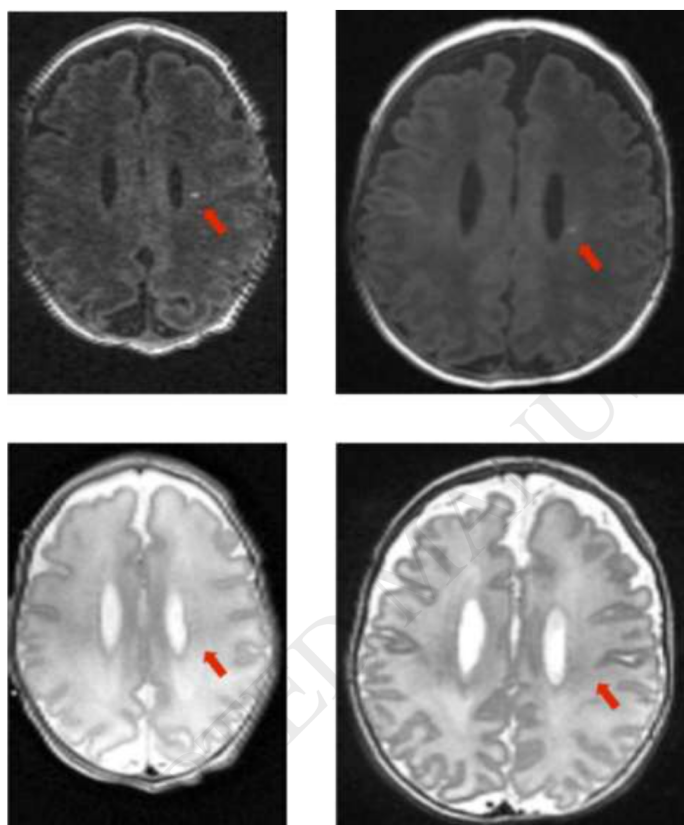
Punctate white matter lesions (red arrows) as seen in axial T1-weighted (top row) and T2-weighted (bottom row) of the same preterm infant born at 29 weeks of gestation imaged for the first time at 33 weeks (left column), and reimaged at 37 weeks of gestation. Acquisition resolution at 1.2mm x 0.78mm x 0.78mm. Note how PWML lesions are readily
